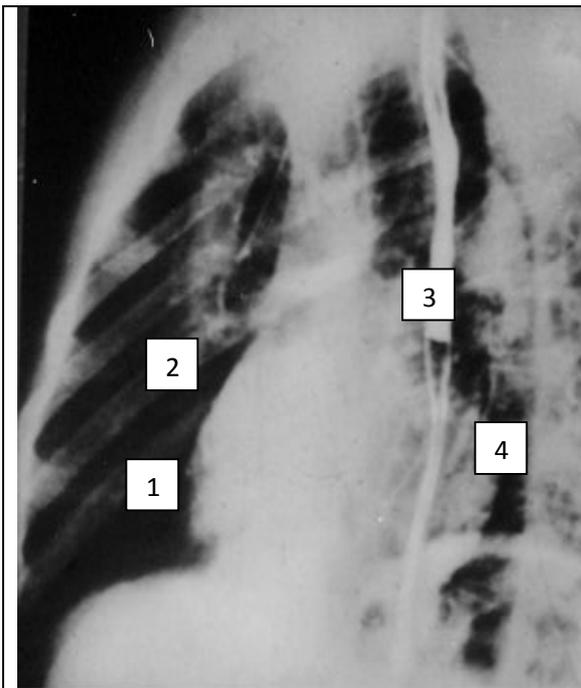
The heart radiograph in the left (second) slanting projection. 1- right ventriculus arch, 2-arch of the right atrium, a 3-arch of the left atrium, 4-arch of the left ventriculus.
